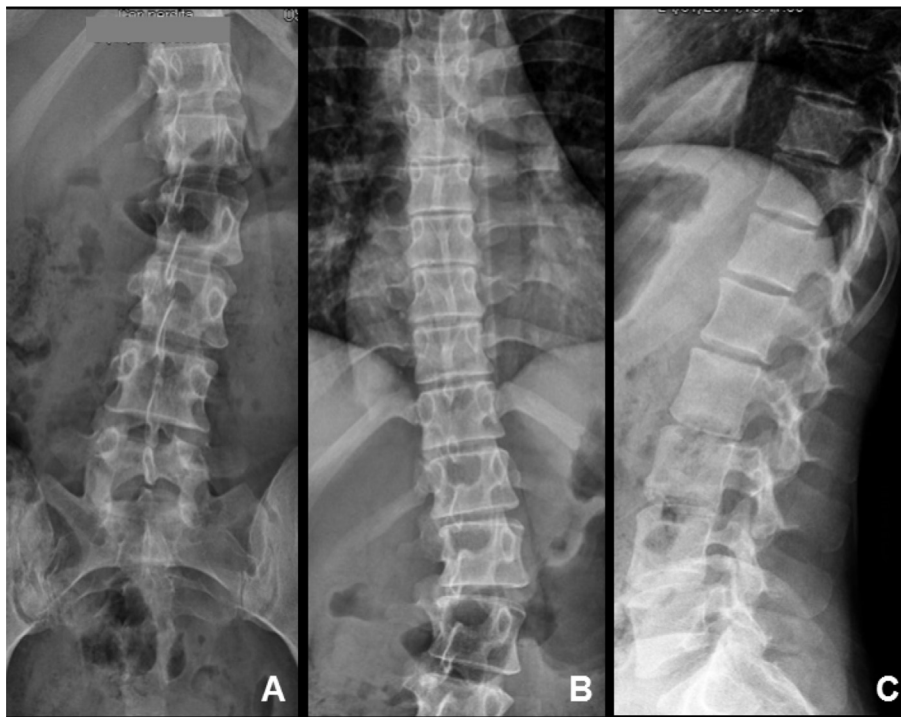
Pre-treatment X-rays. Left convex lumbar scoliosis with the apex comprised between the vertebral bodies of L₁–L₂ (A and B); Reduction in amplitude of intervertebral spaces (C).
